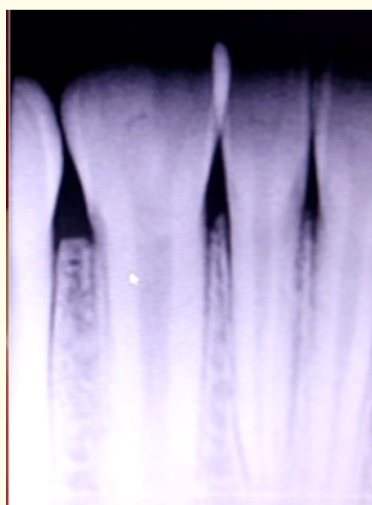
Periapical radiograph showing the presence of a single channel of the wide root, and 1 pulp cavities. Partial twining.
